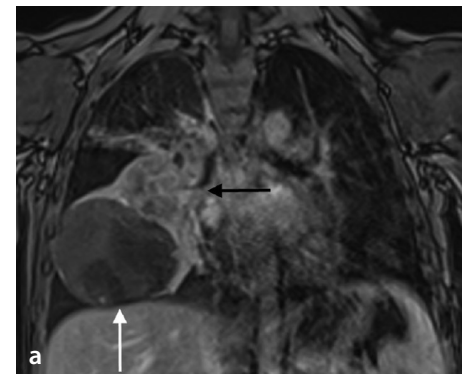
(a-c) A four-year-old boy with type 2 pleuropulmonary blastoma. (a) The coronal post-contrast magnetic resonance image shows a large and heterogeneous tumor with a lobulated margin consisting of solid (black arrow) and cystic (white arrow) parts. (b) The diffusion-weighted image ($b = 800 \text{ s/mm}^2$) and (c) apparent diffusion coefficient map show the diffusion restriction of the solid components of the tumor (arrows).
